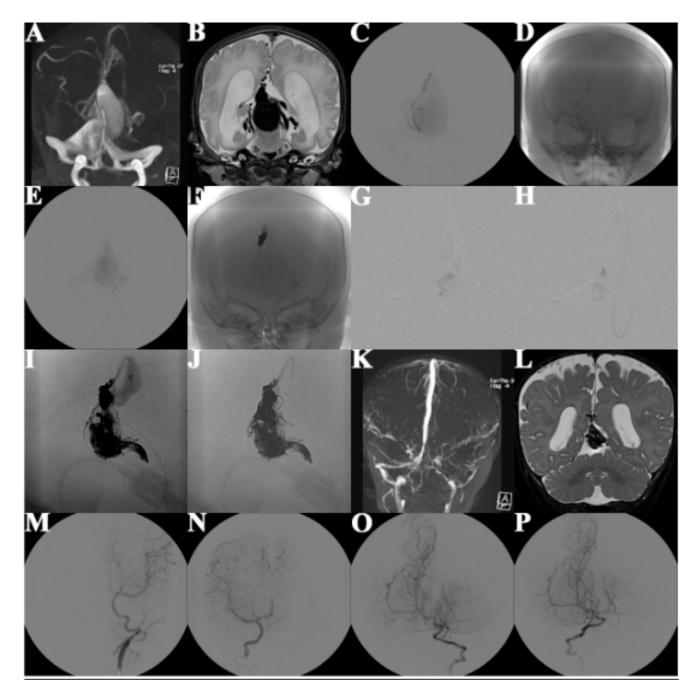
Neurointerventional Treatment–Hemodynamic Stabilization with Repeated Combined Transarterial and Transvenous Embolization in a 1-day-old Patient with VGM Lasjaunias Type 1 "Choroidal". Note: repeated combined transarterial and transvenous embolization ("kissing microcatheter technique") with subsequent hemodynamic stabilization and neurological improvement; (A,B) MRI before embolization showing multiple arteriovenous fistulas and malformations; (C–E) angiography of the arterial feeders (so-called "choroido-thalamic collateral network"); (F–J) repeated combined transarterial and transvenous embolization from different strategic targets with coils and/or EVOH; (K–P) unremarkable MRI at 6-month follow-up.
